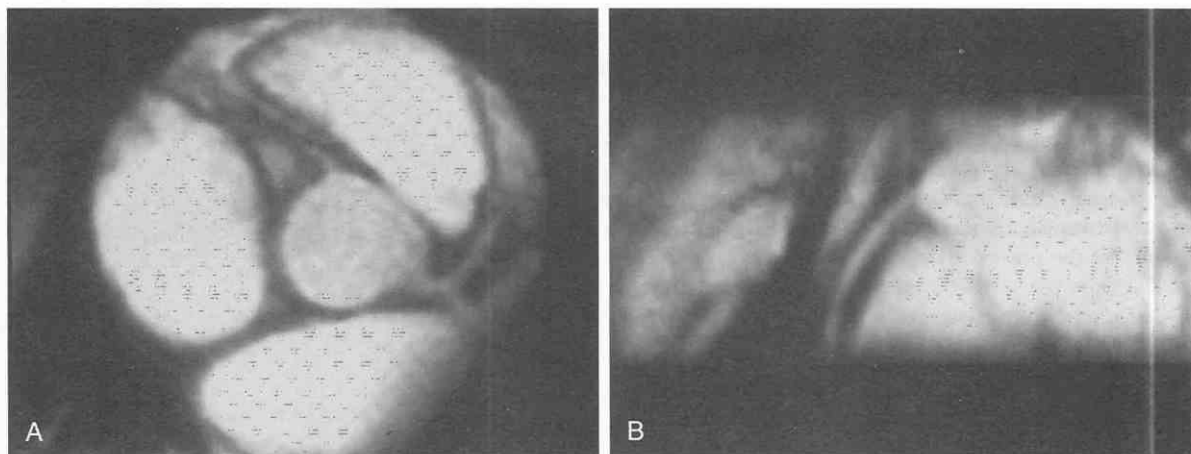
Collecting 32 slices through the heart (all at end-diastole) using a 3D method avoids misregistration artifact inherent in 2D imaging and allows a high-quality multiplanar reconstruction image to be obtained (A). It is then used to search for an appropriate plane to visualize the right coronary artery (B). (From Li D, Paschal CB, Haacke EM, et al: Coronary arteries: Three-dimensional MR imaging with fat saturation and magnetization transfer contrast. Radiology 187:401-406, 1993.)
